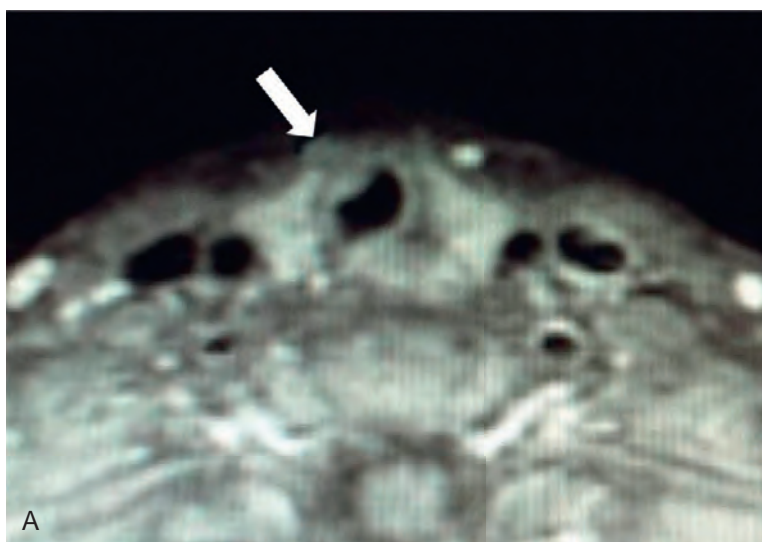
cont'd B, Sagittal view of the MRI showing the cephalocaudad extent of the tumor (arrow).
